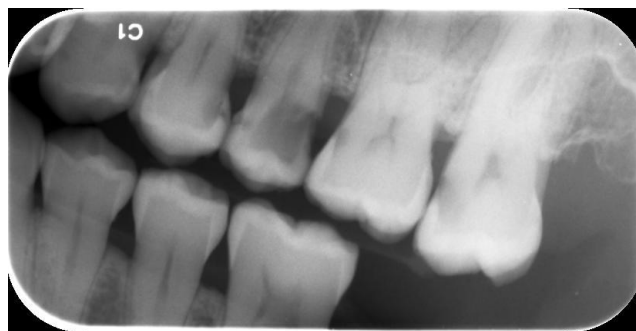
Digital bitewing radiograph with radiolucency in the outer half of dentin (R3).
